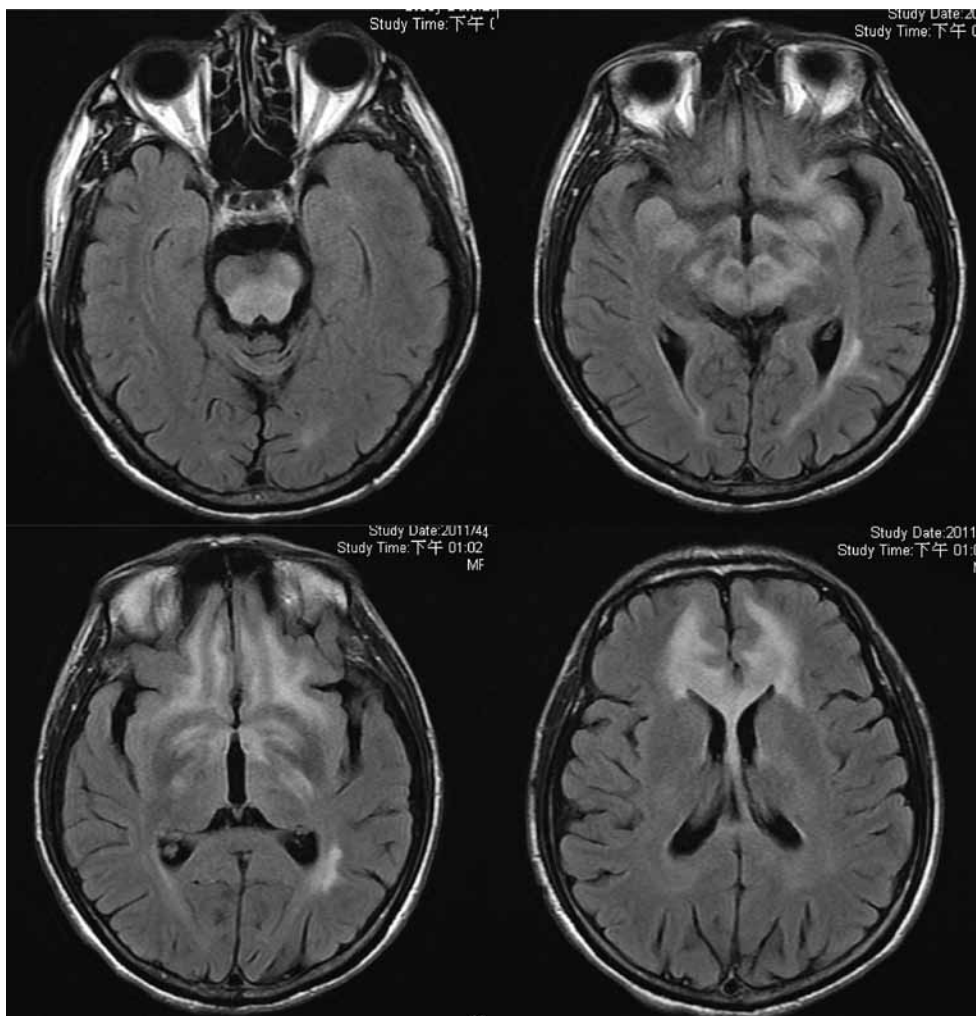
The FLAIR images of brain magnetic resonance imaging showed symmetric subcortical hyperintensity in bilateral frontotemporal and basal ganglia, dorsal pontine, and midbrain.
